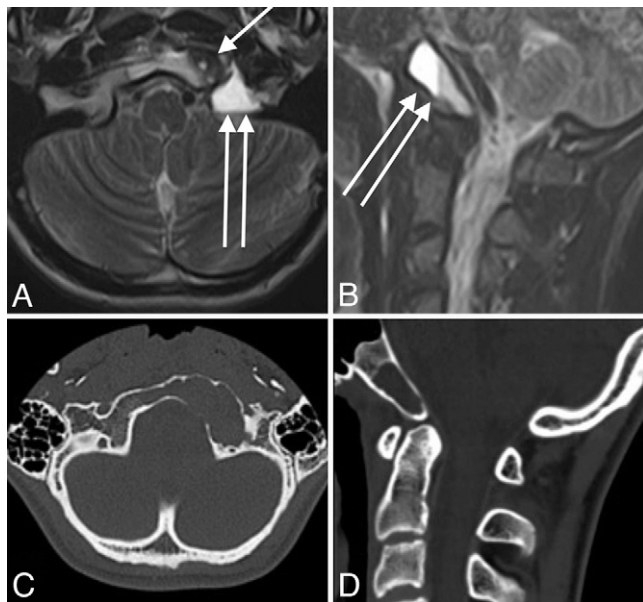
Pretreatment skull base MR and CT images. A: Axial T2-weighted MR image shows the left side of the clivus filled with nodular low signal material (single arrow) and the left occipital condyle completely replaced with cystic disease containing a blood fluid level (double arrows). B: Midline sagittal short tau inversion recovery image showing an additional fluid portion replacing the clivus from the foramen magnum up to the basioccipital synchondrosis with blood fluid level (double arrows). C: Axial noncontrast CT image at the same level as in panel A, showing bone destruction of the clivus and left occipital condyle. D: Midline sagittal CT image at the same location as in panel B, showing midline clival bone destruction.
